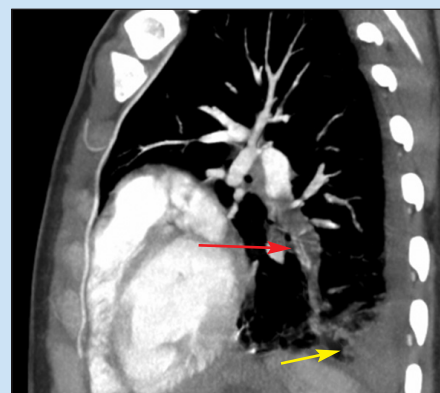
Sagittal CT reformation demonstrates left lower lobe pulmonary embolism (red arrow) with a wedge-shaped pulmonary infarct posteriorly (yellow arrow).
